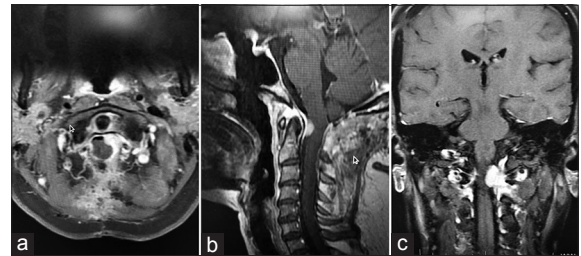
Postoperative contrast-enhanced magnetic resonance imaging (a) axial, (b) sagittal, (c) coronal images showing complete resection of the right-sided meningioma with the left-sided residual tumor.
